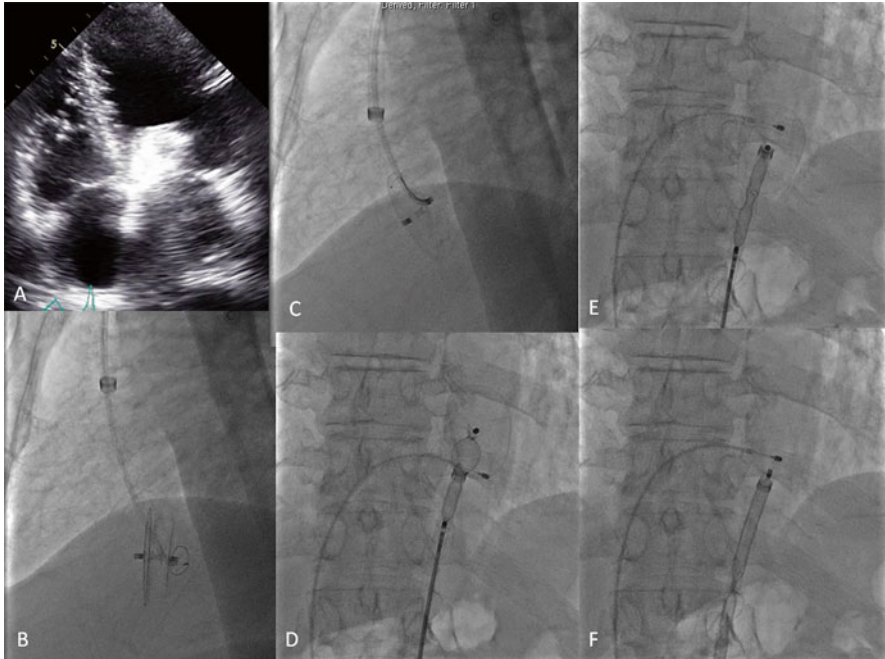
Percutaneous retrieval of embolized 28 mm ACP device lodged in the left ventricular outflow tract. (a) Transthoracic echocardiogram image of the embolized device (*arrow*) in the left ventricle. (b) A 14F 80 cm sheath was delivered from the femoral artery to the ascending thoracic aorta. A 5Fr JR4 guide was then delivered through the sheath into the left ventricle. A 10 mm gooseneck snare was delivered through a 5F JR4 guide into the left ventricle. (c) The gooseneck snare was cinched onto the distal endscrew and the device was pulled up vertically against the aortic valve. (d) The partially recaptured device was pulled into the descending thoracic aorta, but the snare came loose and a bioptome (*arrow*) was used to grab onto the endscrew within the sheath. (e) With firm grasp of the bioptome, the lobe of the device was entirely retrieved. (f) With further firm pulling, the entire device was retrieved into the 14F sheath
